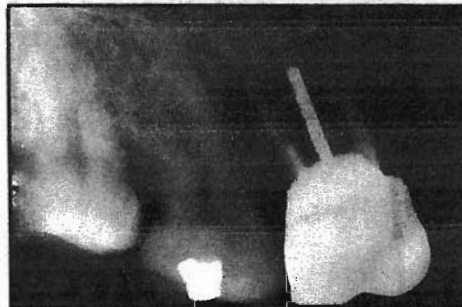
Endodontic failure that eventually caused a mesial radiographic lesion. Surgical exploration, however, revealed massive palatal bone destruction that eventually led to two unsuccessful periapical and periodontal surgeries.
